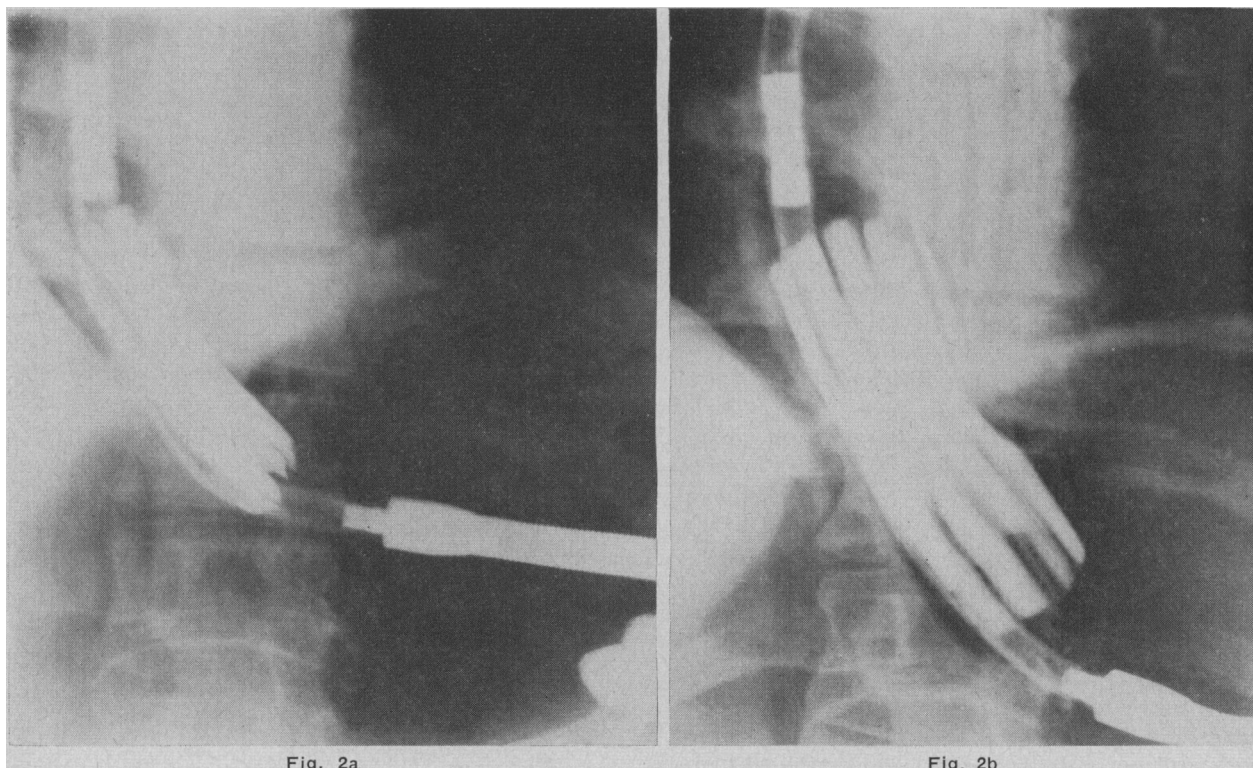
Radiograph of Moshier bag in position through the cardia. (a) Before distension. (b) Distended to 15 lb. to the square inch. Note indentation by cardia.
